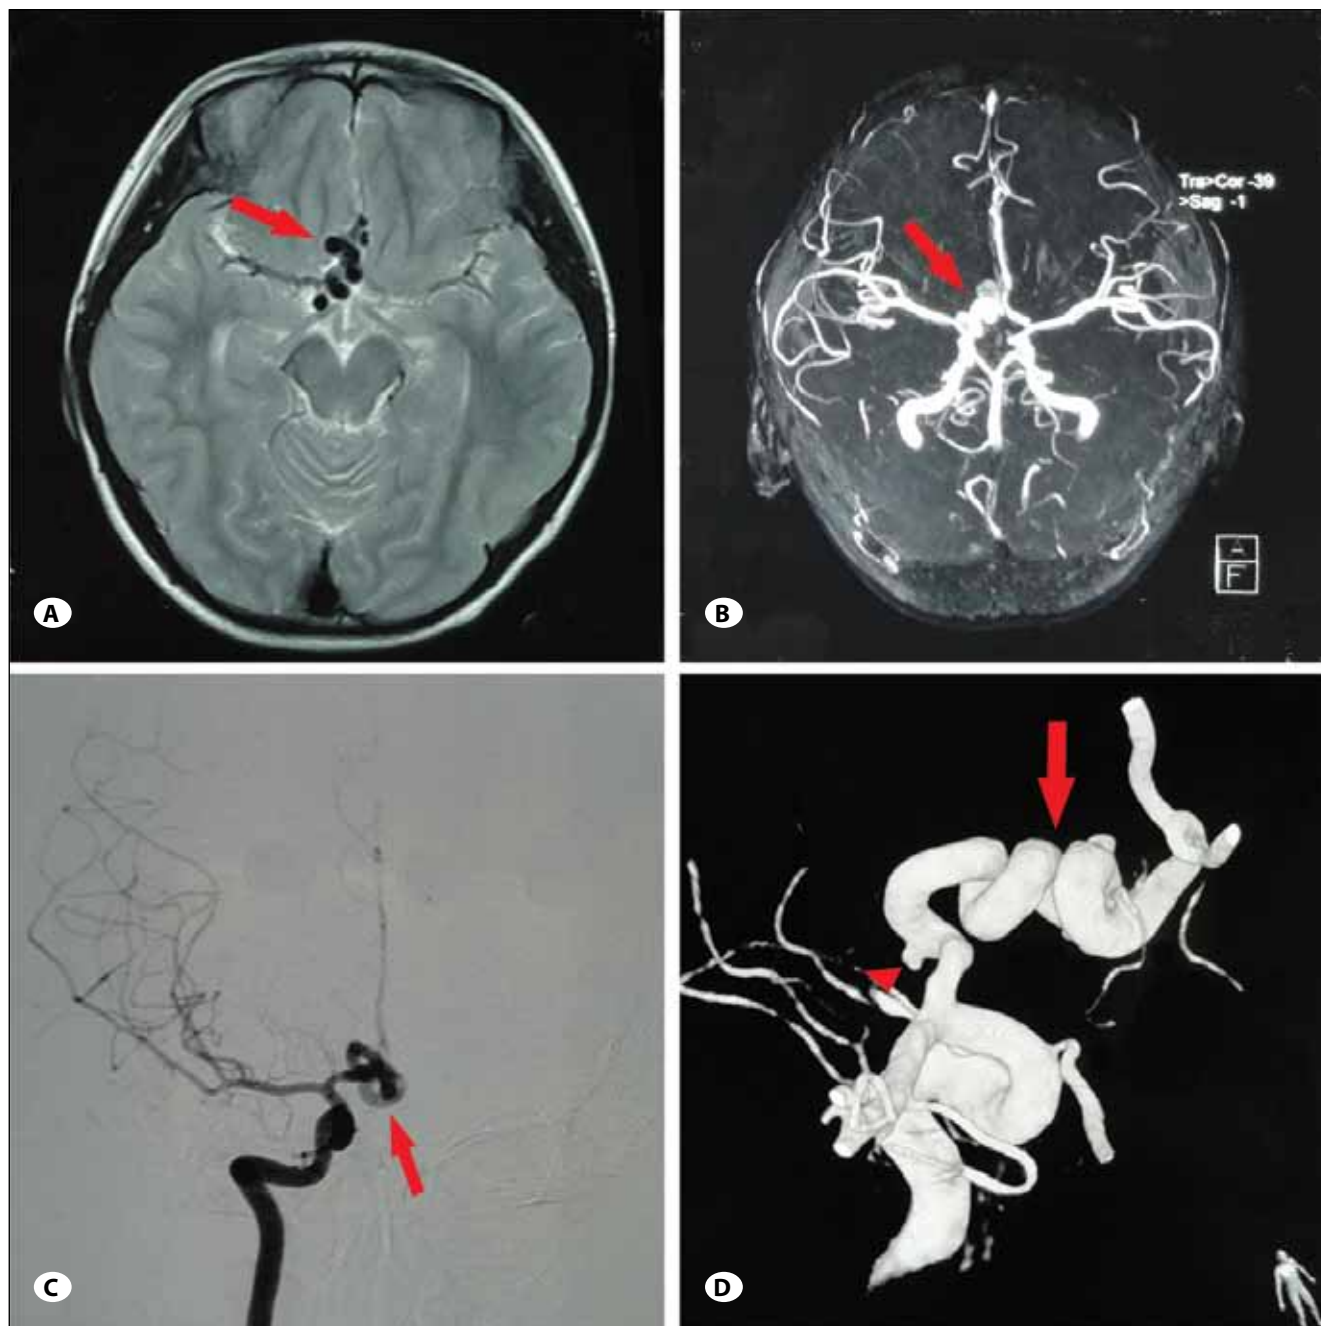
A) Brain MRI showed arteriovenous malformations (red arrow). B) MRA revealed severe abnormalities in anterior cerebral artery (red arrow). C,D) DSA confirmed the elongation and tortuosity in the A1 and A2 segments of right anterior cerebral artery (red arrow) and a small aneurysm formation in proximal end of anterior cerebral artery (red arrowhead).
